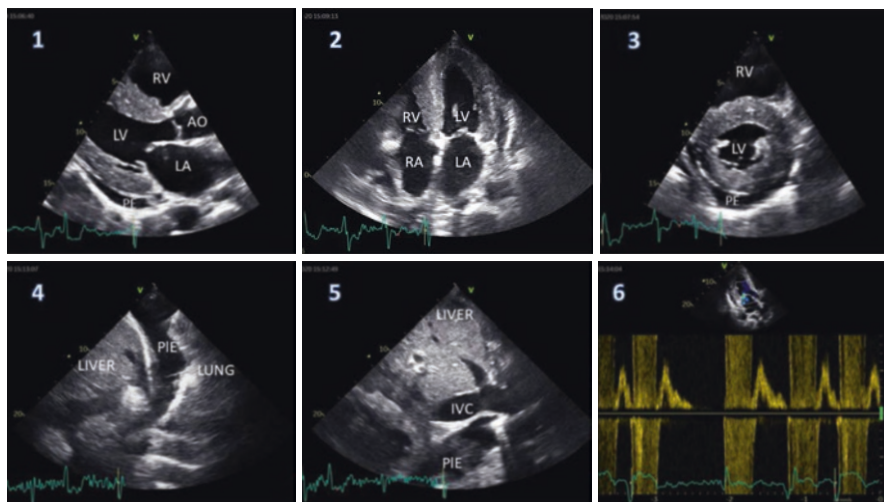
1—Parasternal long axis showing valve thickening, pericardial effusion, left ventricular hypertrophy with a bright and sparkling appearance; 2—apical four-chamber presenting biatrial enlargement, right ventricular hypertrophy, interatrial septal thickening; 3—parasternal short axis with right ventricular enlargement, pericardial effusion and left ventricular hypertrophy; 4—lung ultrasound showing pleural effusion; 5—subcostal view with dilated inferior vena cava; 6—mitral flow disclosing irregular rhythm and mitral regurgitation. *AO* Aorta, *IVC* Inferior vena cava, *LA* Left atrium, *LV* Left ventricle, *PE* Pericardial effusion, *PIE* Pleural effusion, *RA* Right atrium, *RV* Right ventricle
